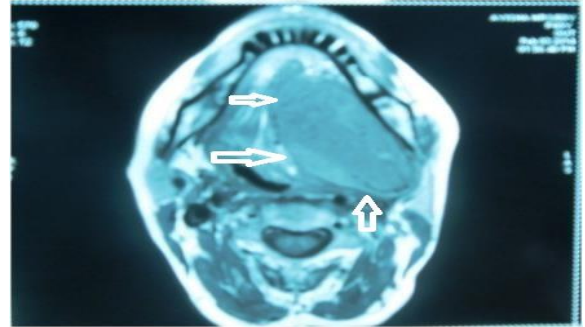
MRI showing coronal section.
